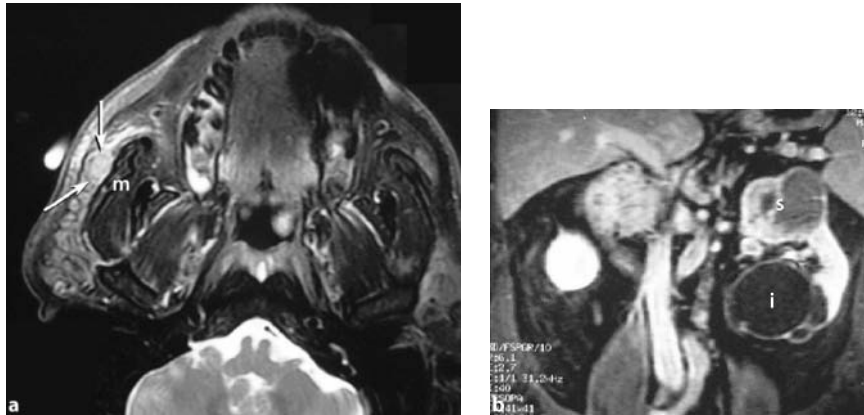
a T2-weighted axial MRI through the parotid gland demonstrates a round 10-mm mass (arrows) overlying the masseter muscle (*m*). The mass has signal intensity slightly higher than the adjacent gland, but not high enough to be definitive for pleomorphic adenoma. This proved to be renal cell carcinoma metastatic to the accessory lobe. b Sagittal postcontrast spoiled-gradient MRI of the abdomen with T1 weighting shows two distinct masses in the left kidney. The superior mass (*s*) has cystic and solid components. The inferior mass (*i*) is predominantly cystic and has extensive septations
